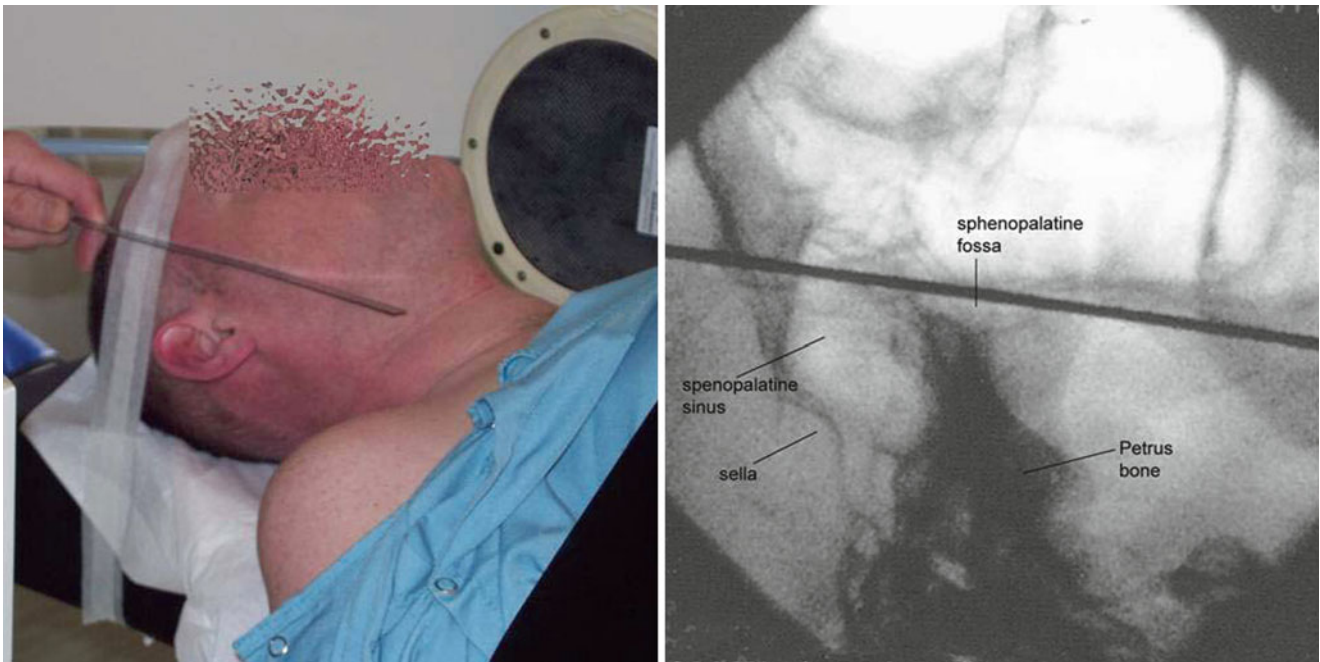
Metal ruler projected over the fossa pterygopalatina, patient and fluoroscopic, X-ray lateral view
